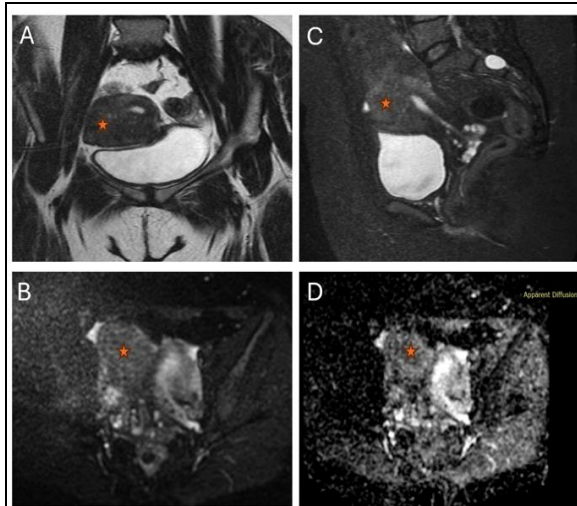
Uterine adenomyosis (*) - shows iso to mildly hyperintense signal on Cor T2W (A) and ill defined hyperintense signal on Sag STIR images (C) with effaced endo-myometrial interface in this region. DWI (B) & ADC (D) images - No diffusion restriction.
